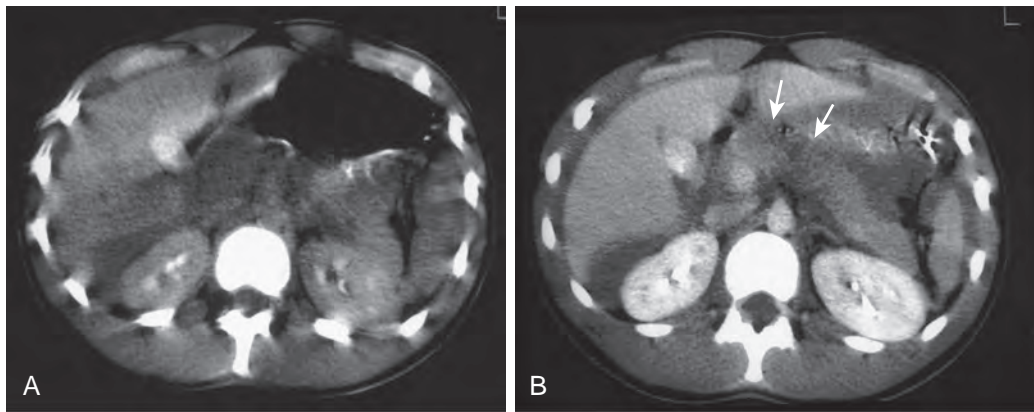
Pancreatic contusion. A. The CT scan through the upper abdomen of a young girl involved in a motor vehicle accident is limited by significant motion artifact. B. The repeated scan through the upper abdomen shows heterogeneous low attenuation in an enlarged pancreas that represents pancreatic contusion and edema (arrows). The patient also has moderate free intraperitoneal fluid.
